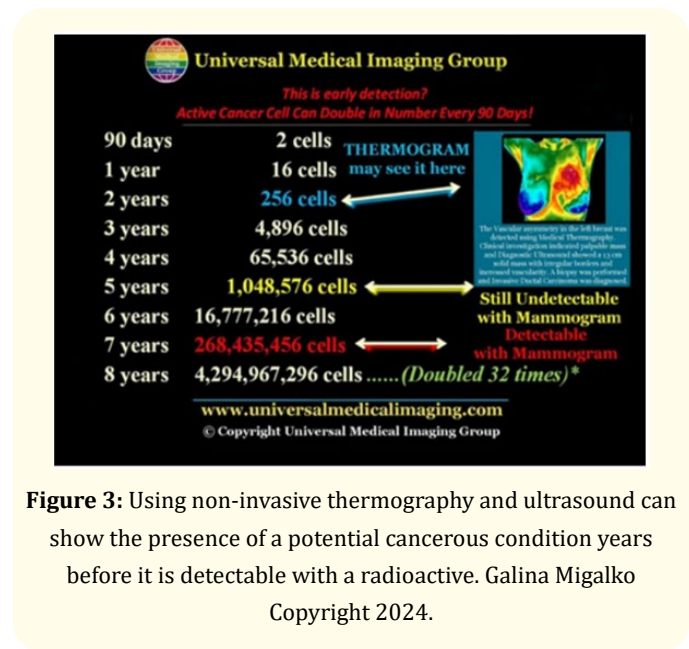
Using non-invasive thermography and ultrasound can show the presence of a potential cancerous condition years before it is detectable with a radioactive. Galina Migalko Copyright 2024.
